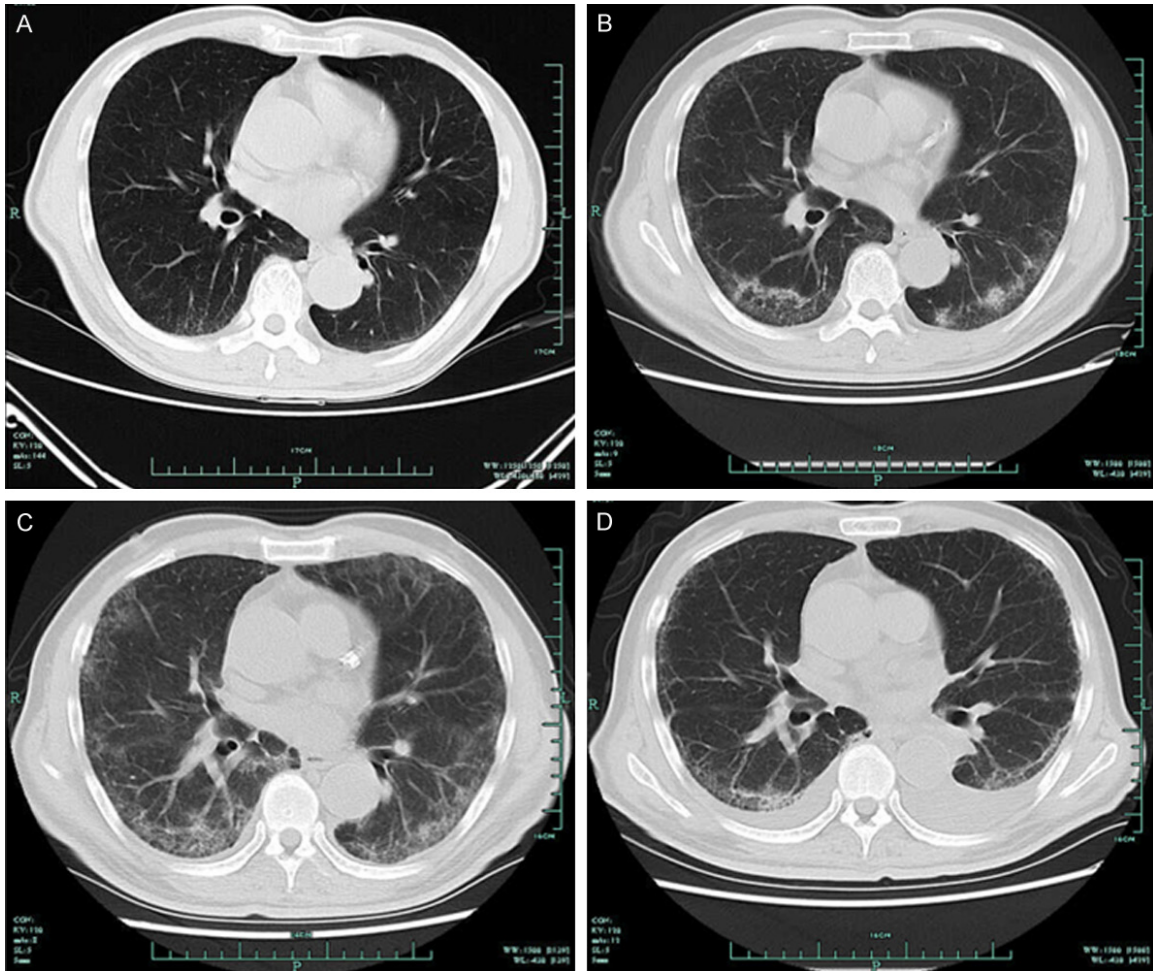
CT scan of the chest. (A) before cetuximab treatment, (B) after the eighth cycles' treatment of cetuximab, (C) after the eleventh cycles' treatment of cetuximab, (D) 2 months after admission of steroid pulse therapy.
